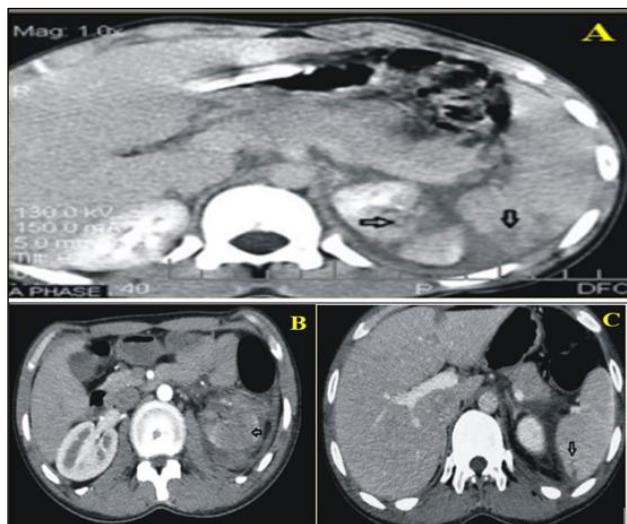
CT images showing multiple solid organ injuries; A: Grade III left kidney with grade II splenic injury; B: Grade IV left kidney with grade I splenic injury (A); C: Grade IV left kidney with grade I splenic injury (B).
